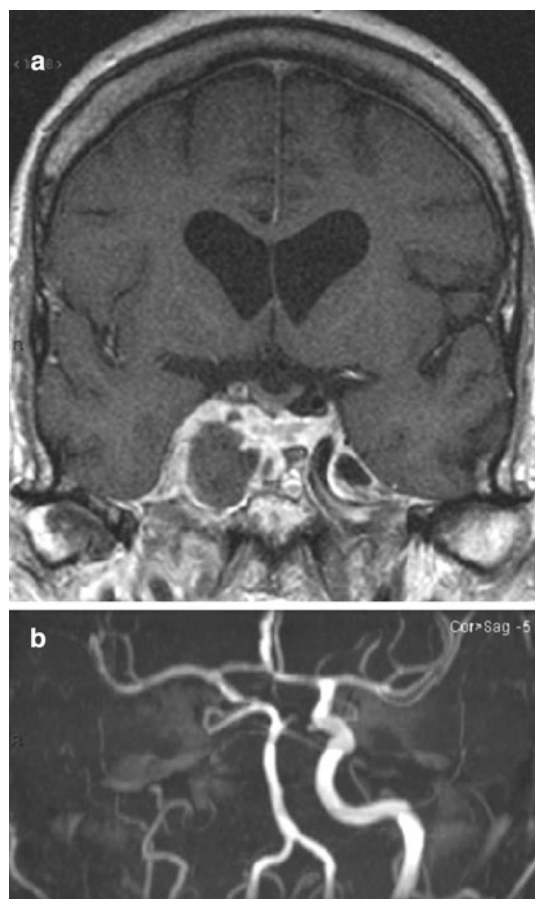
MR work-up in May 2007: a contrast-enhanced coronal T1-weighted image showing mass effect of the right cavernous sinus with enhanced peripheral rim surrounding central unenhanced fresh thrombus. b Frontal reformat of TOF angiogram demonstrating absence of flow within both extra-cranial and intra-cavernous segments of right ICA. Flow within distal segment of ICA and middle cerebral artery is preserved by collateral vicariance through communicating arteries resulting in the absence of acute parenchymal ischemic lesion, even on diffusion-weighted images (not shown)
